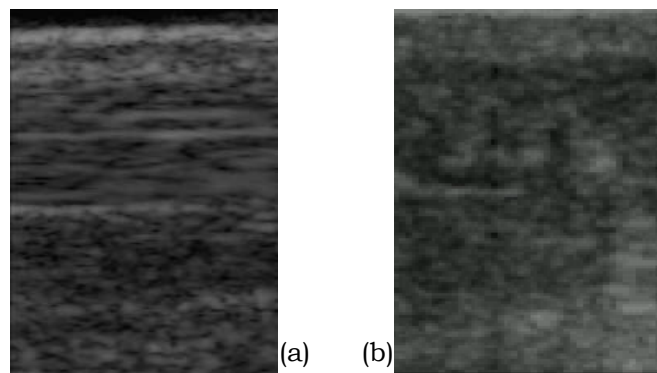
Typical ultrasound images of Achilles tendons. (a) Normal; (b) Healed.
